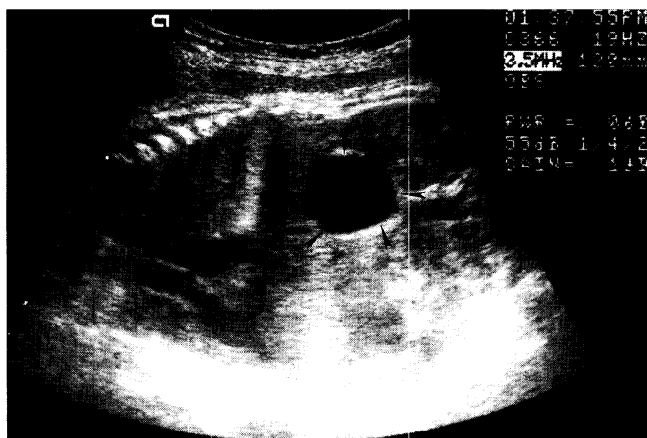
Fetal sonogram at 37 weeks' gestation, showing an anechoic simple cyst (arrowheads) superior to the right kidney
